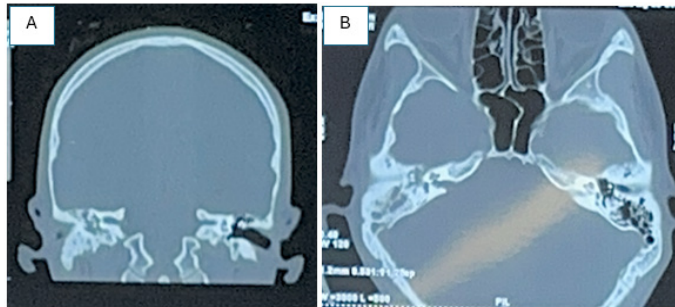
Preoperative contrast-enhanced computed tomography (CT) of the temporal bone.
